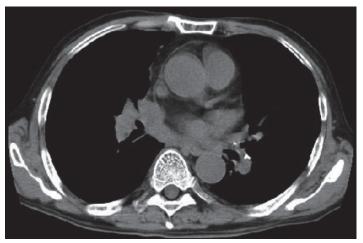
Chest computed tomography demonstrating a partial response to chemotherapy in the primary lung lesion.
